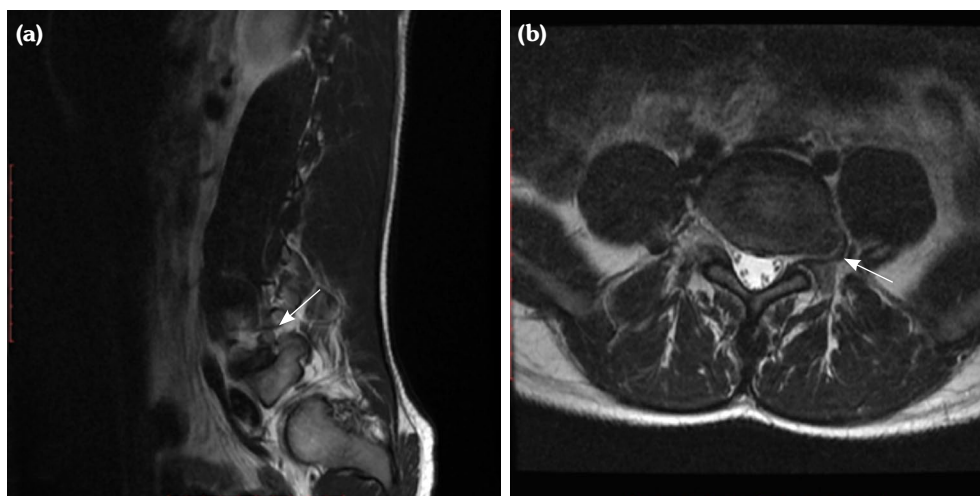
Preoperative MRI images. (a) Sagittal T2WI, disc herniation (arrow). (b) Axial T2WI disc herniation (arrow).
